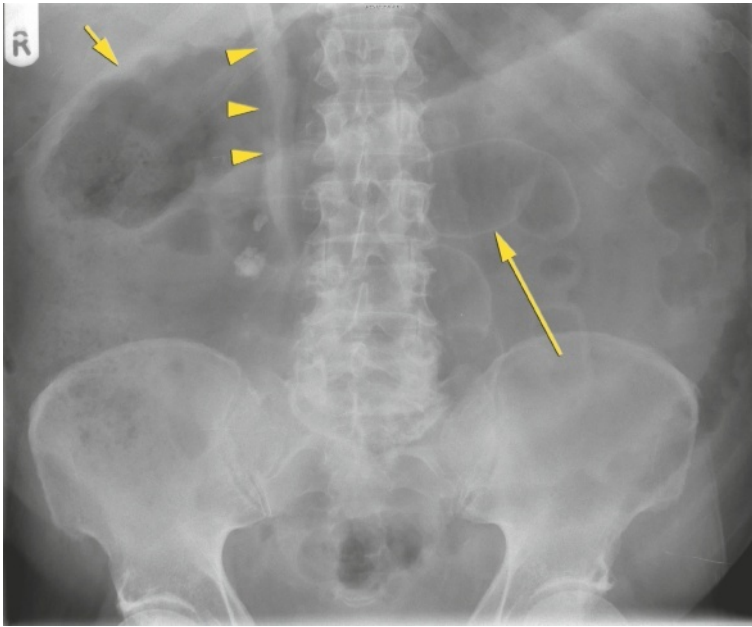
Plain abdominal radiograph showing a grossly dilated caecum (arrowheads) twisted about an abnormally placed mesentery (long arrow)
